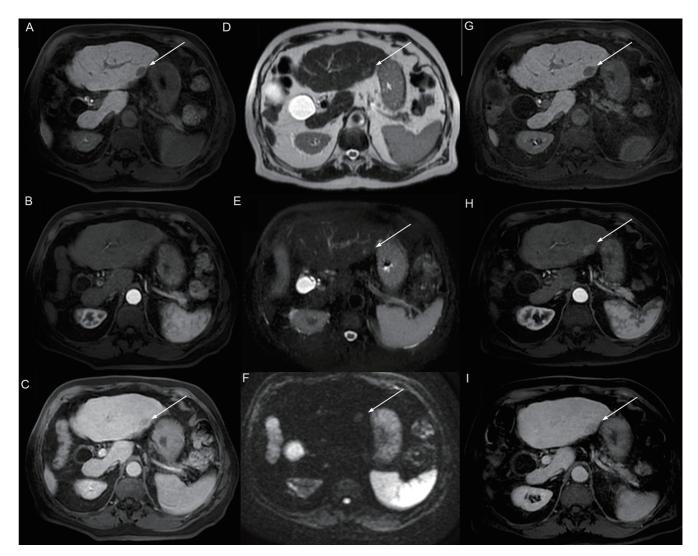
Axial MR images demonstrate a 17 mm nodule in the liver segment 2. (A–C) It appears hypointense in the hepatobiliary phase (HBP) compared to the surrounding parenchyma (arrow in A), is not visible in the arterial phase (B) and shows washout in the portal venous phase (arrow in C). (D–F) The same nodule also appears slightly hyperintense in both T2-weighted and fat-saturated T2- weighted images (arrow in D and E, respectively) and corresponds to a moderate diffusion restriction in diffusion-weighted imaging (DWI) (arrow in F). (G–I) Follow-up axial MR images of the same nodule performed after 6 months demonstrated a slight dimensional increase in HBP (21 mm vs. 17 mm) (arrow in G) and the appearance of arterial phase hyperenhancement (arrow in H); this latter imaging feature, paired with the persistence of washout in the portal venous phase (arrow in I), allowed the noninvasive diagnosis of overt hepatocellular carcinoma (HCC).
